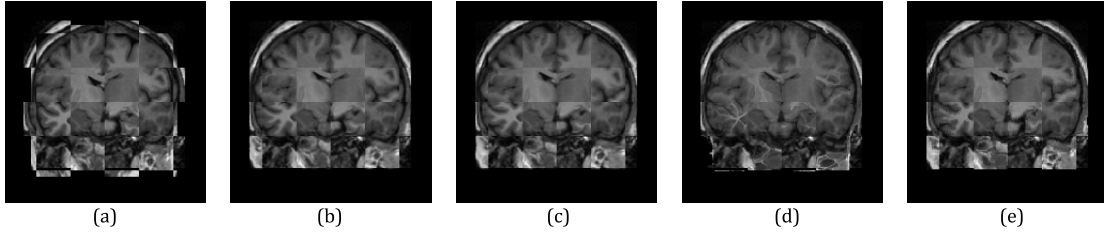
Visual results on multi-subject MRI data. Results are shown as a checkerboard, where neighboring tiles come from different subjects. (a) Source-target pair before registration (b-e) After registration using (b) MIND (c) SSC (d) DROP and (e) Proposed method.
